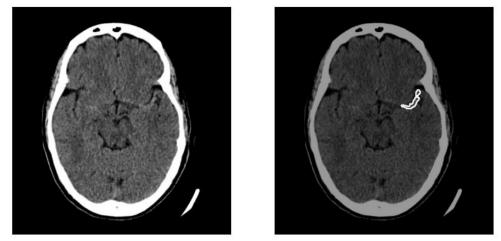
Al algorithm (NeuralAssist, TeleradTech) demonstration of hyperdense middle cerebral artery sign on a noncontrast CT scan of the brain performed in the setting of acute stroke.
